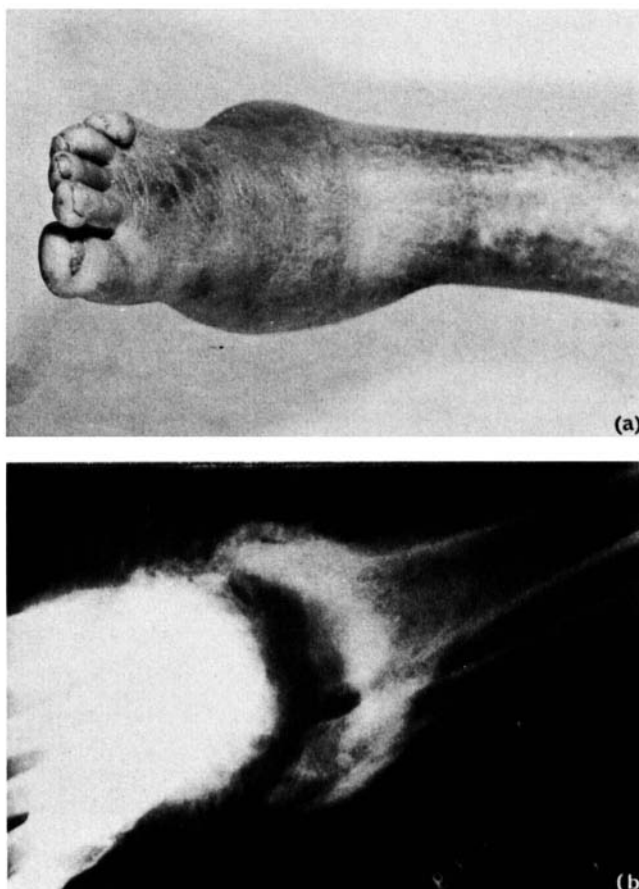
(a). Soft fluctuant swelling of the ankle area without heat or obvious inflammation; (b) radiograph of (a). The lesion commenced as a fracture of the talus and calcaneum 5 years earlier.
